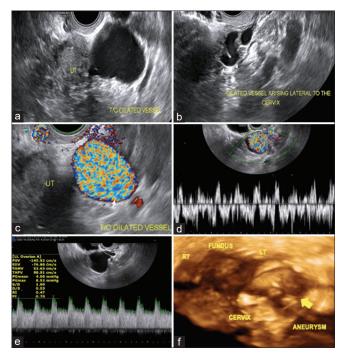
Gynecologic Doppler studies: (a) Grayscale image showing cystic structure lateral and inferior to the left side of the uterus measuring 4.06 cm × 3.58 cm × 4.18 cm (volume 31.80 mL). (b) Serpentigious structure adjacent the cystic structure is a blood vessel arising from the uterine isthmus suggestive of the uterine artery. (c) Color flow mapping of the cystic structure showing abundant and mixed colors. (d) Color Doppler of the cystic structure showed bidirectional turbulent flow. (e) Color Doppler of the adjacent serpentigious structure showed pulsative waveforms. (f) 3D image of the uterus with adjacent cystic structure (yellow arrow). All findings are suggestive of uterine artery aneurysm. PSV: Peak systolic velocity, UT: Uterus, RT: Right adnexa, LT: Left adnexa
